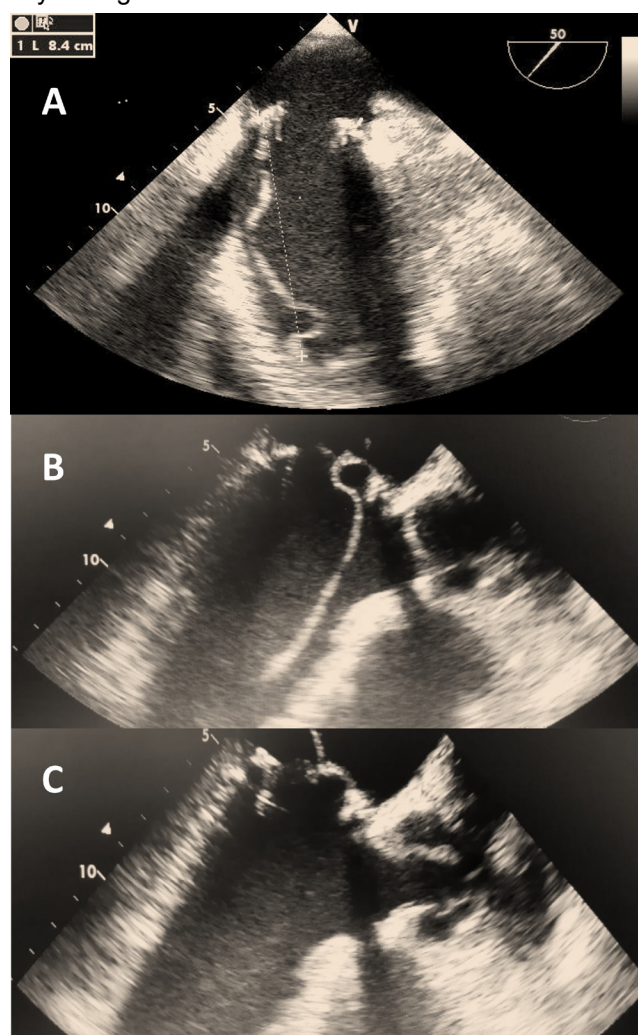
Images obtained by transesophageal echocardiography: mobile filamentous vegetation in the left ventricle measuring 84 mm along its major axis (A), anchored to the leaflet of the mitral bioprosthesis (B), and occasionally projecting through the aortic valve during the cardiac cycle (C).
